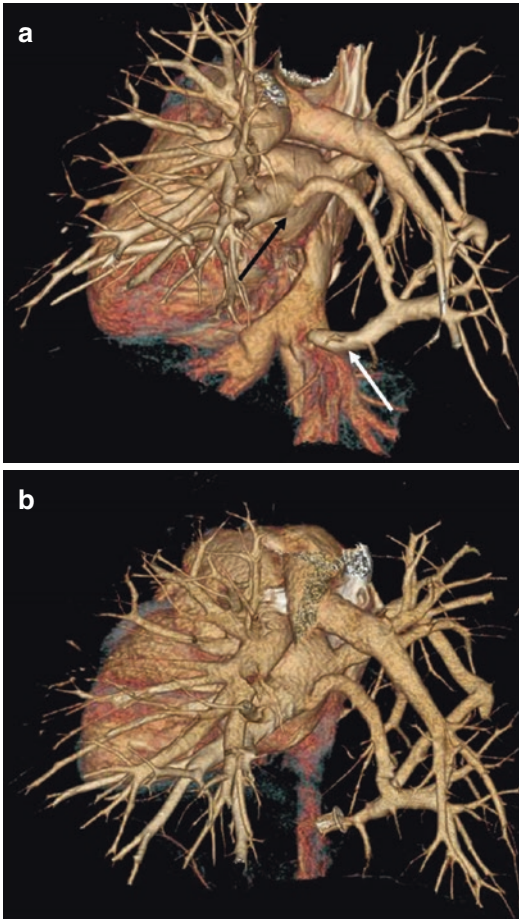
Pseudo-scimitar syndrome at CT angiography. (a) Posterior oblique volume rendering image demonstrates a right inferior pulmonary vein draining abnormally into the inferior vena cava (*white arrow*) and also into the left atrium (*black arrow*). (b) Posterior oblique volume rendering image from CT angiography realized after percutaneous intervention shows a device occluding the connection between the right inferior pulmonary vein and inferior vena cava
